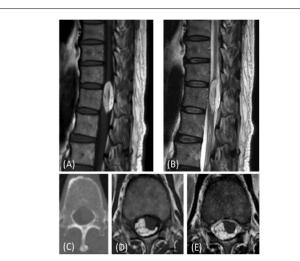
Case 1. Lumbar spinal magnetic resonance images. Preoperative sagittal and axial images showed a high intensity area at T12 on T1WI (A and D) and T2WI (B and E). CT showed widening of the spinal canal with spreading and thinning of the pedicles at T12 (D).
